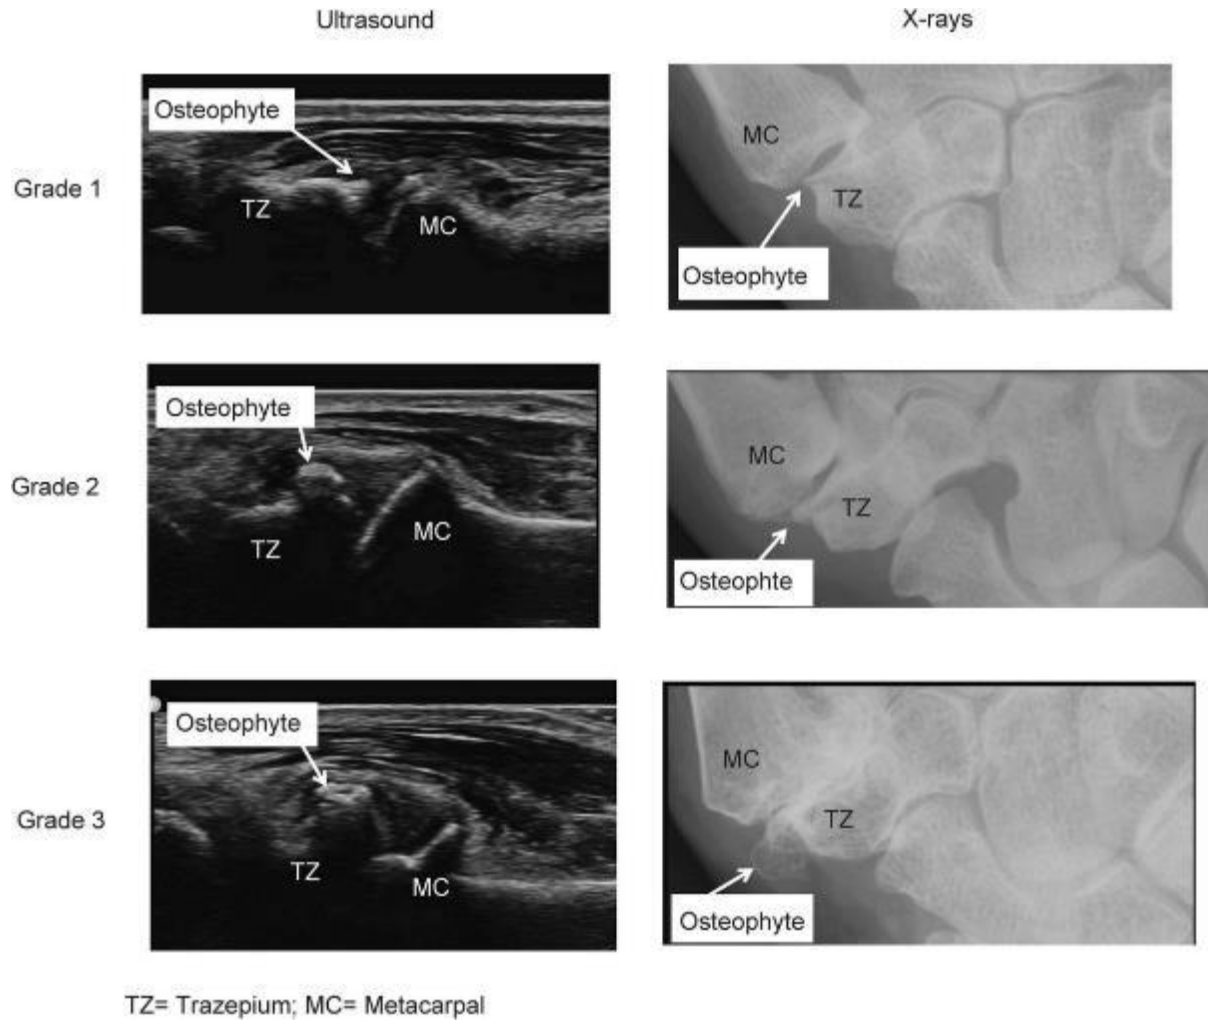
Atlas for Osteophyte grading of ultrasound and plain radiograph in our sample
